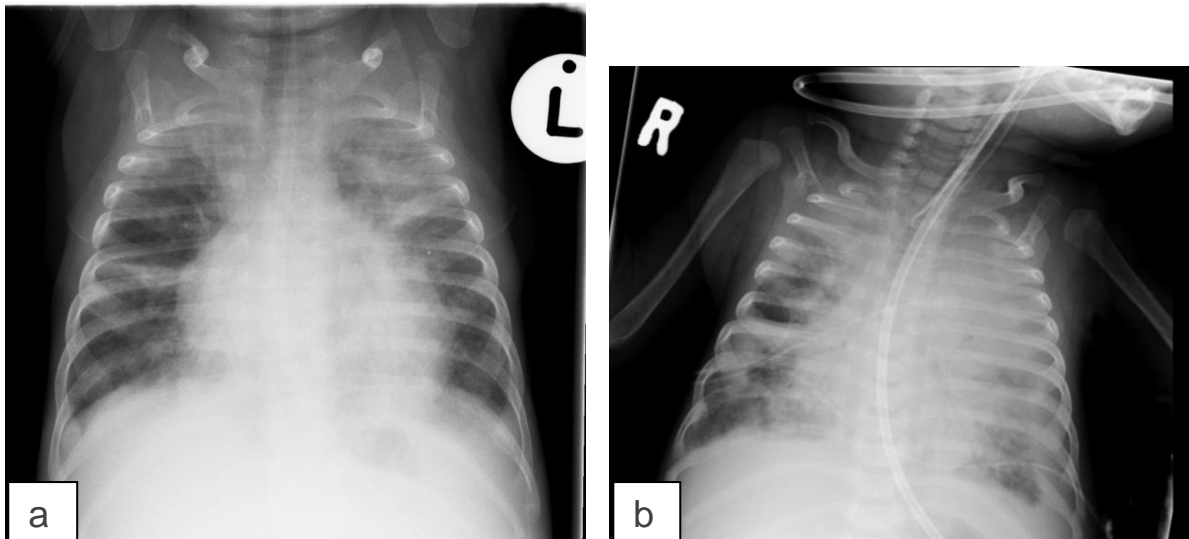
(a) CXR taken pre-ART in a 4 month old child newly diagnosed with HIV infection. Xray shows: Multifocal airspace disease involving both upper lobes, right middle lobe, left lingular and left lower lobe. (b) CXR, 5 weeks post-ART initiation in the same child as above. He had been readmitted for worsening respiratory distress.
